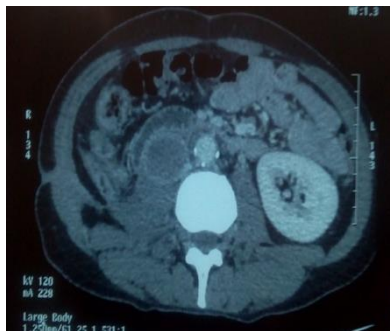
CT scan view of retroperitoneal hematoma with a right artery renal aneurysm
